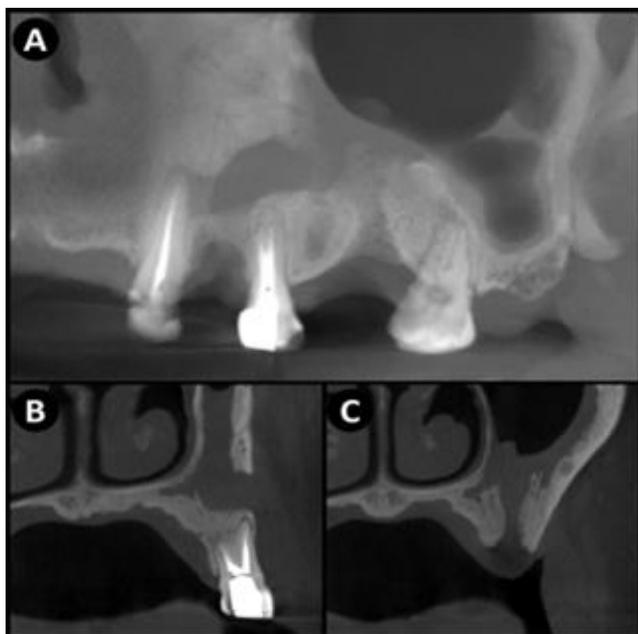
CBCT performed 7 days after the surgical procedure. A – CBCT, panoramic reconstruction. B – CBCT, coronal reconstruction demonstrating the surgical access performed. C – CBCT, coronal reconstruction demonstrating the region of the oroantral communication.
